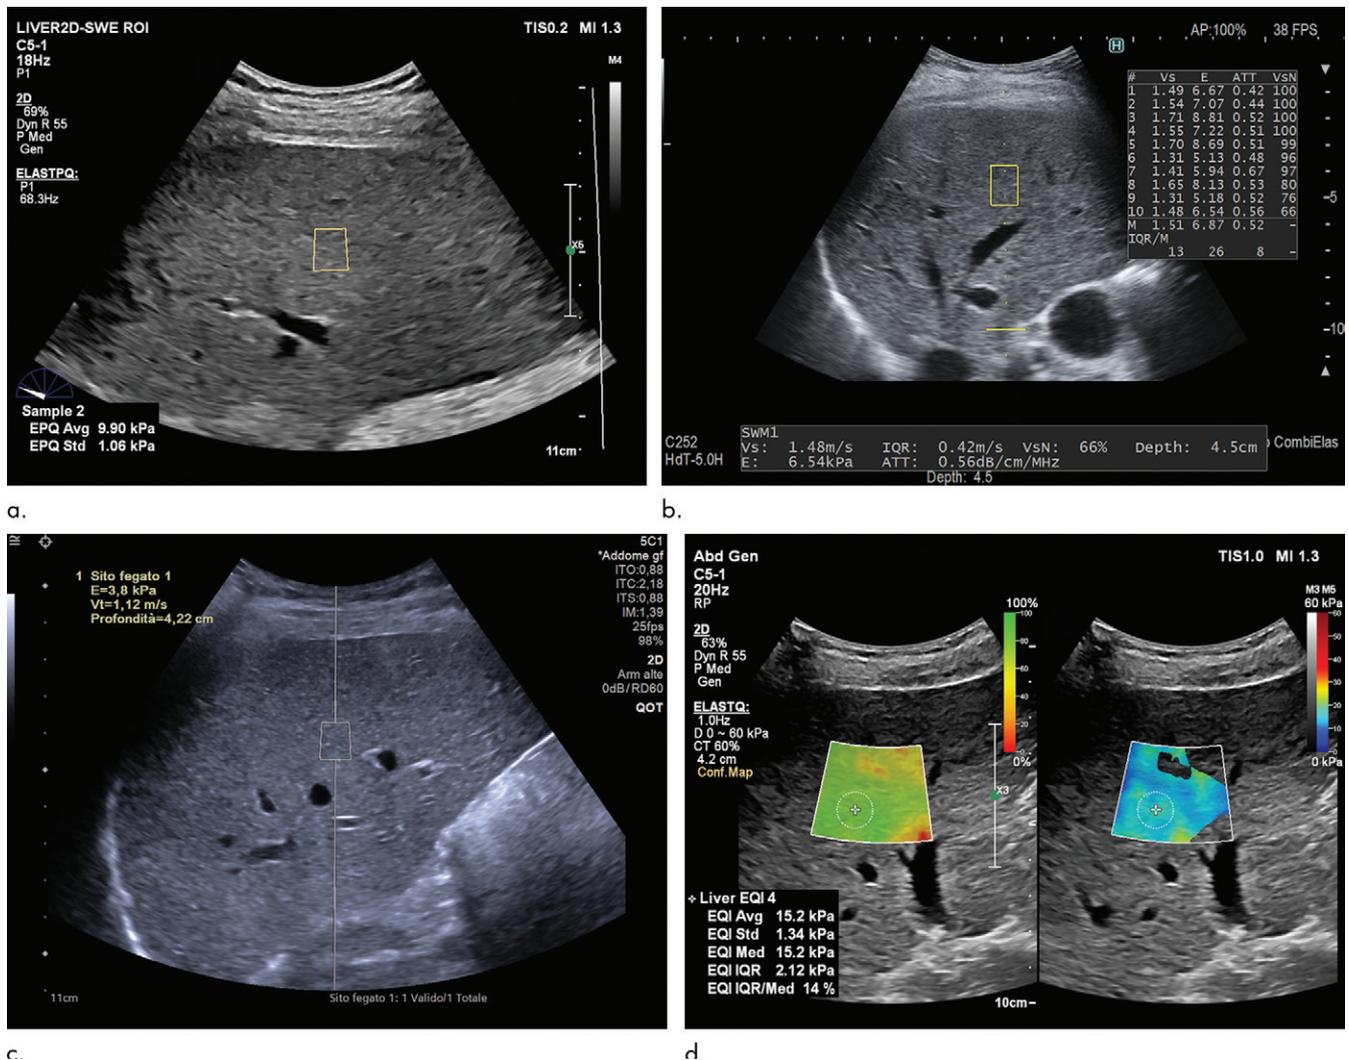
(a) Image obtained with point shear-wave elastography (pSWE) system (ElastPQ; Philips, Bothell, Wash). A standard deviation (Std) of 30% or less of the mean value is indicative of an acquisition of good quality. In this case, the standard deviation is 1.06/9.90 or 10.7%. When the signal-to-noise ratio of an acquisition is very low, the mean value is not shown. (b) Image obtained with pSWE (SWM1; Hitachi, Tokyo, Japan). “VsN” is a reliability index that indicates the percentage of effective push-track sequences. When the signal-to-noise ratio of an acquisition is very low, the mean value is not shown. A good acquisition has a VsN of at least 50%. In this case, the VsN measurements are all above 66%. (c) Image obtained with pSWE (VTQ; Siemens, Mountain View, Calif). The system automatically filters out the measurements that are not good. In these cases, the numeric value of shear-wave speed is replaced by an “XXX” sequence. (d) Images obtained with two-dimensional (2D) shear-wave elastography (SWE) (EQI, Philips). The color-coded confidence map (left) is an evaluation of the quality of the acquired signals. The confidence threshold (CT) is set at 60%: Areas of low quality (red) are filtered out and left blank on the color-coded image of liver stiffness assessment (right); the yellow color on the confidence map is a warning, that is, it indicates that the acquisition in that area is not the highest quality (Fig 1 continues).
